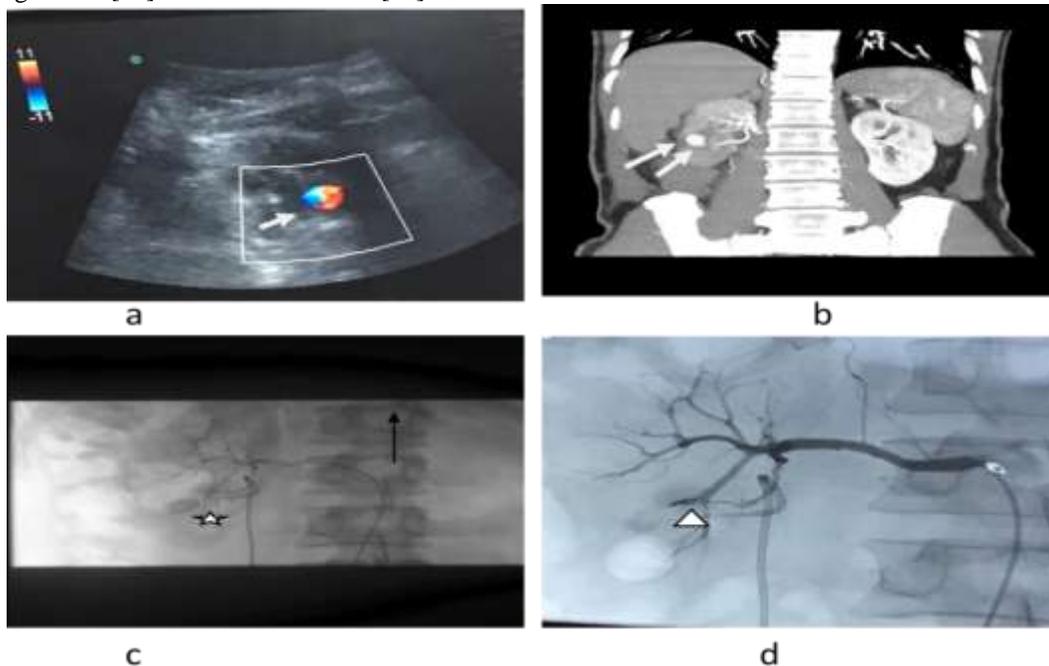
Renal artery pseudoaneurysm: 37year old presented with gross hematuria on 7th day after PCNL with DJ stenting for nephrolithiasis. USG Doppler Yin yang (white arrow) flow (a) and CT renal angiography(b) shows typical features of RAP (two white arrows) at lower pole. Selective DSA renal angiography(c) confirms the diagnosis of RAP (star) and subsequently embolized (d) with Nester coils (triangle)
